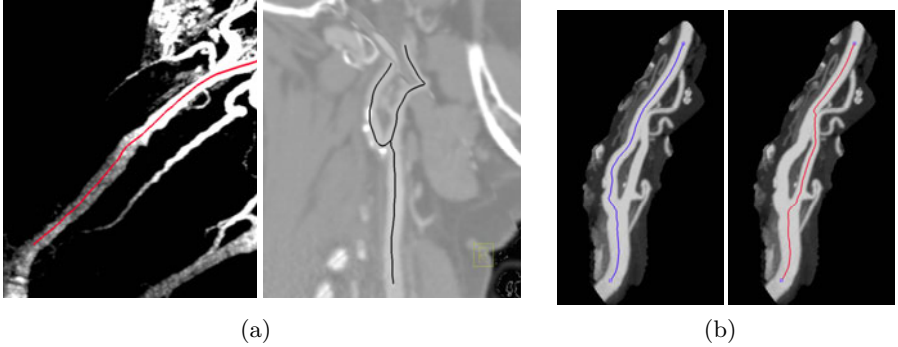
Selected results of the minimal path detection algorithm: (a) Accurate centerline extractions, (b) Two distinct paths (red: *erroneous*, blue: *correct*) on a carotid artery in CE-CTA. The extraction is affected by the presence of a nearby structure.
